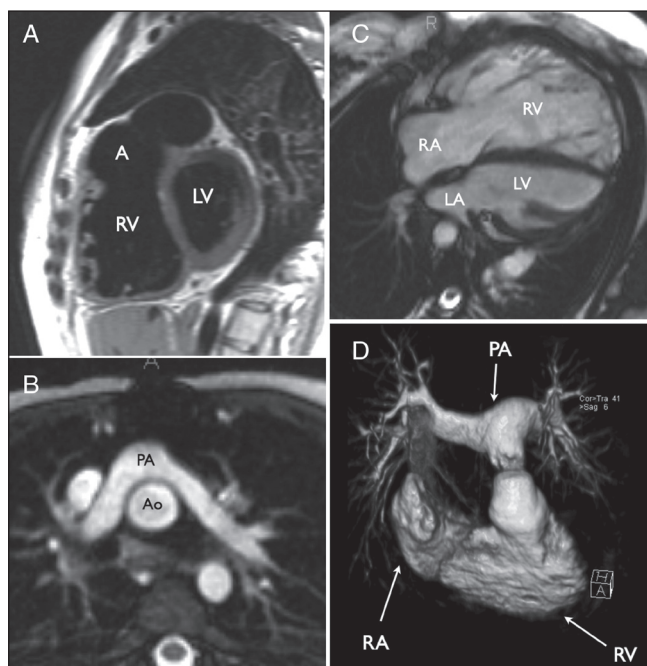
Examples of cardiovascular magnetic resonance imaging of congenital heart disease. A Sagittal black-blood image of a patient with repaired tetralogy of Fallot, showing right ventricular dilation and an aneurysm (A) of the right ventricular outflow tract patch. B Transverse static bright-blood image (steady-state free precession) of the pulmonary arteries (PAs) lying anterior to the aorta (Ao) following arterial switch repair with the Lecompte manoeuvre in transposition of the great arteries. C Diastolic frame of a steady-state free precession cine image series in a patient with repaired tetralogy of Fallot and pulmonary regurgitation showing severe right ventricular dilation. D Volume rendering of a gadolinium-enhanced magnetic resonance angiogram of the right ventricle (RV) and PAs in a patient with an RV-to-PA-valved conduit for repair of pulmonary atresia and ventricular septal defect. LA Left atrium; LV Left ventricle; RA Right atrium
